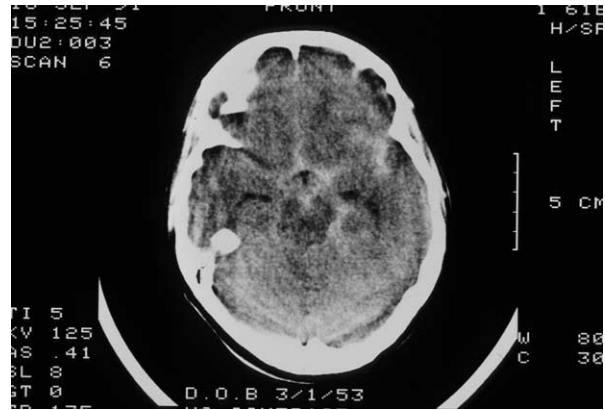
This patient was found collapsed with a Glasgow Coma Scale of 5. The computed tomography head scan shows widespread blood within the subarachnoid spaces. At autopsy, a saccular aneurysm of the anterior communicating artery was found to be the source of the hemorrhage.
